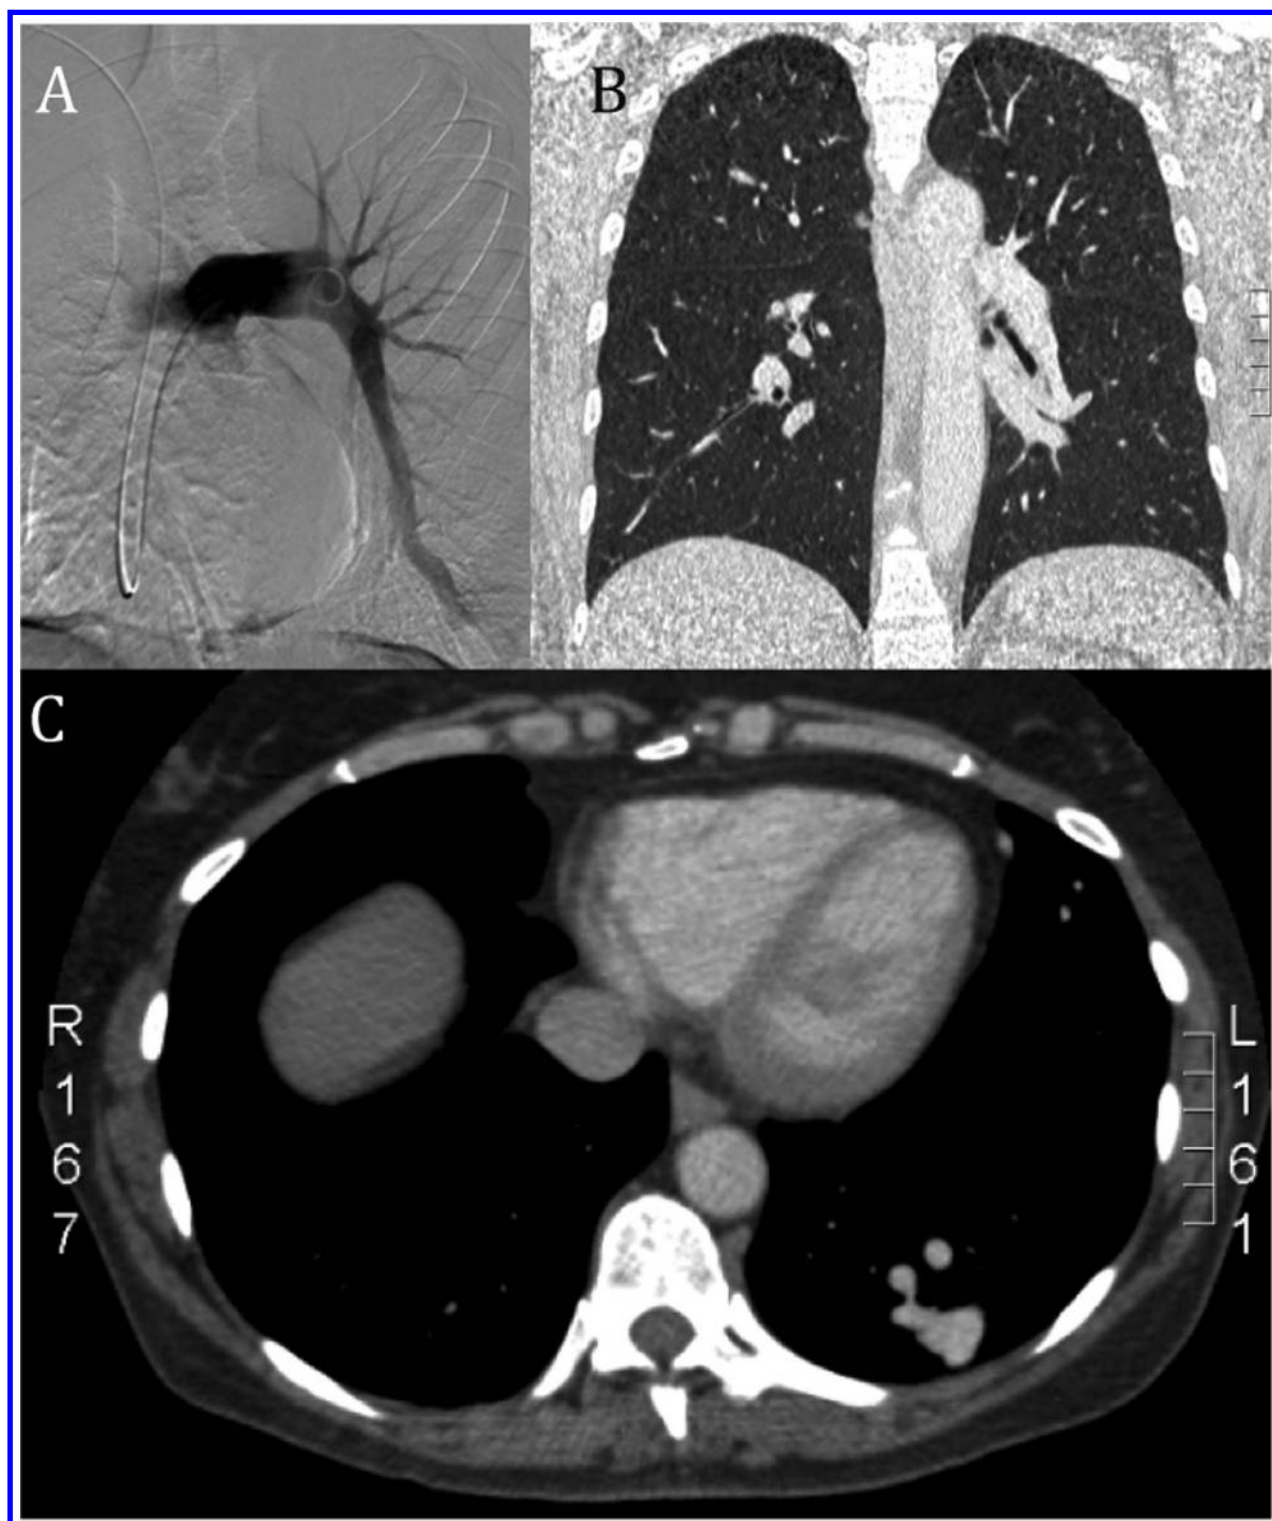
Pulmonary angiography (A) and CT findings (B, C). Axial and coronal contrast-enhanced CT scan (B, C) reveals aneurysmal enlargement and arterio-venous malformation of the left lower lobe pulmonary artery, but no evidence of intraluminal thrombi. These findings were confirmed by contrast-enhanced angiography (A).
